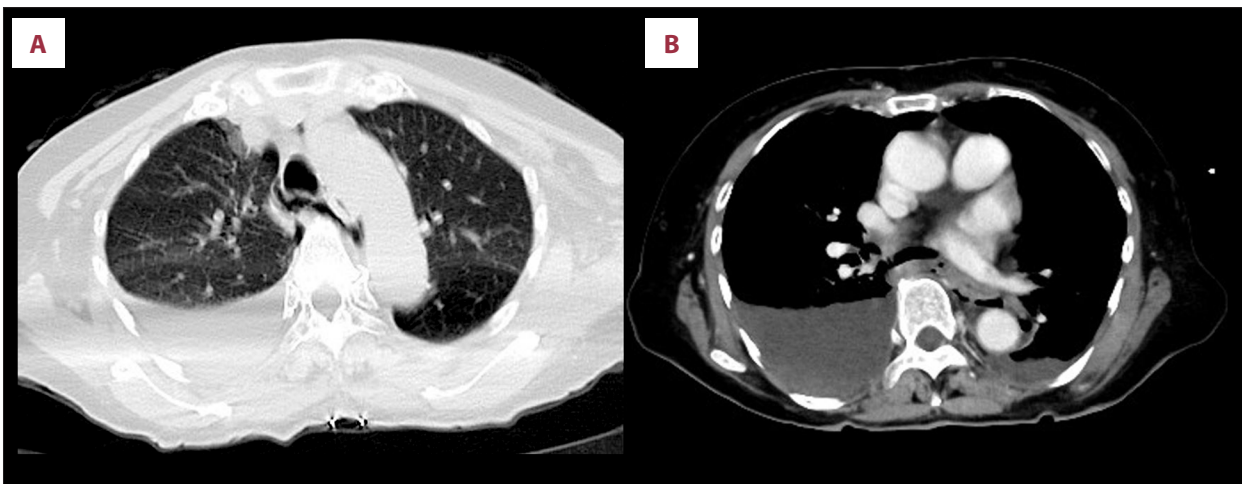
(A, B) Contrast-enhanced computed tomography revealing pneumomediastinum with periesophageal air, right pneumothorax, and right pleural effusion containing a high-density component.
